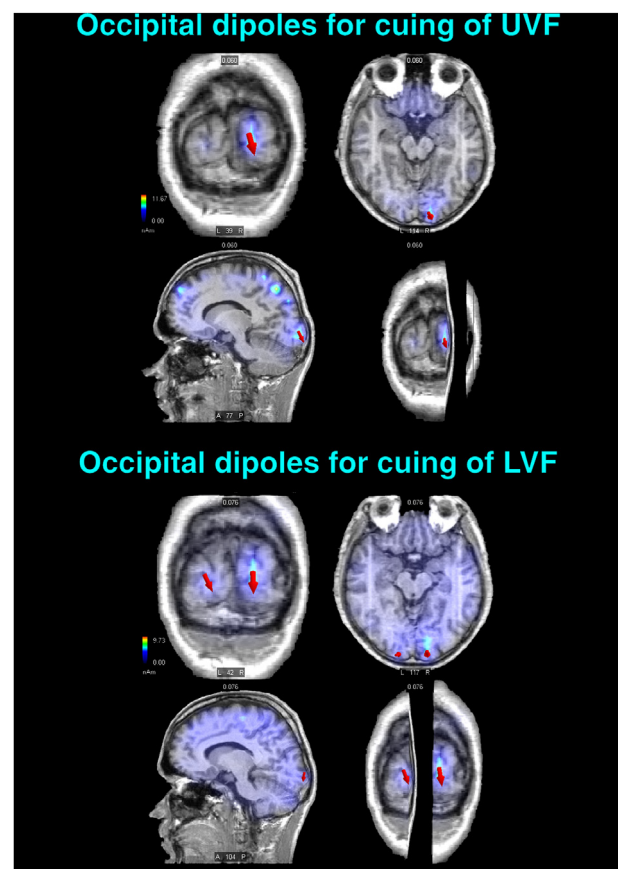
Selected striate-occipital sources of sLORETA inverse solutions computed in the C1 latency range (i.e., 60–75 ms) of the P-N80 complex for the LC - CC DW relative to the cuing of visuospatial attention toward either the UVF (Left) or the LVF (Right). The active equivalent dipoles overimposed on realistic (left-to-right) coronal, axial, parasagittal, and 3D T1-weighted MRI brain images are drawn as red arrows with different sizes according to their magnitudes and different orientations according to their flowing direction. Upper Panel: a prominent source of activation localized in the right-sided striate occipital portion of the lingual gyrus (LG, BA 17; ROI = 2 mm) is shown for the UVF. Lower Panel: equivalent dipoles reflecting active sources localized in the striate occipital portions of both the lingual and cuneus gyri (BA 17; ROI = 2 mm) of both hemispheres elicited by the cuing of LVF. Note that the complete list of all the active dipoles obtained by means of the sLORETA inverse solutions for C1 and detailed information about their features are reported in Table 2. L = Left; R = Right.
